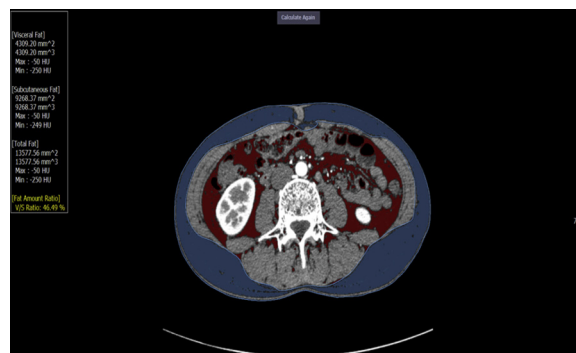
Axial computed tomography images of the level of the umbilicus used for assessment of abdomen adiposity. The red region represents the visceral adipose tissue, and the blue area represents the subcutaneous adipose tissue.
